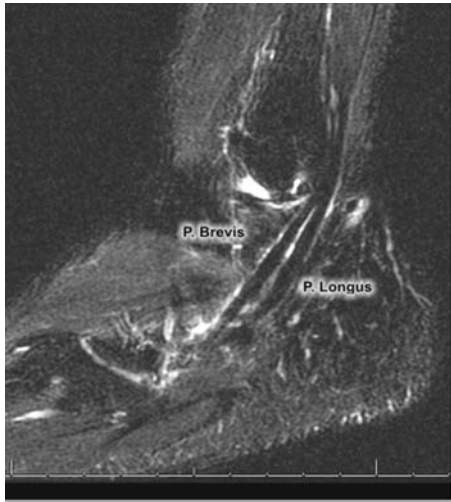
Sagittal T2-weighted MRI.
